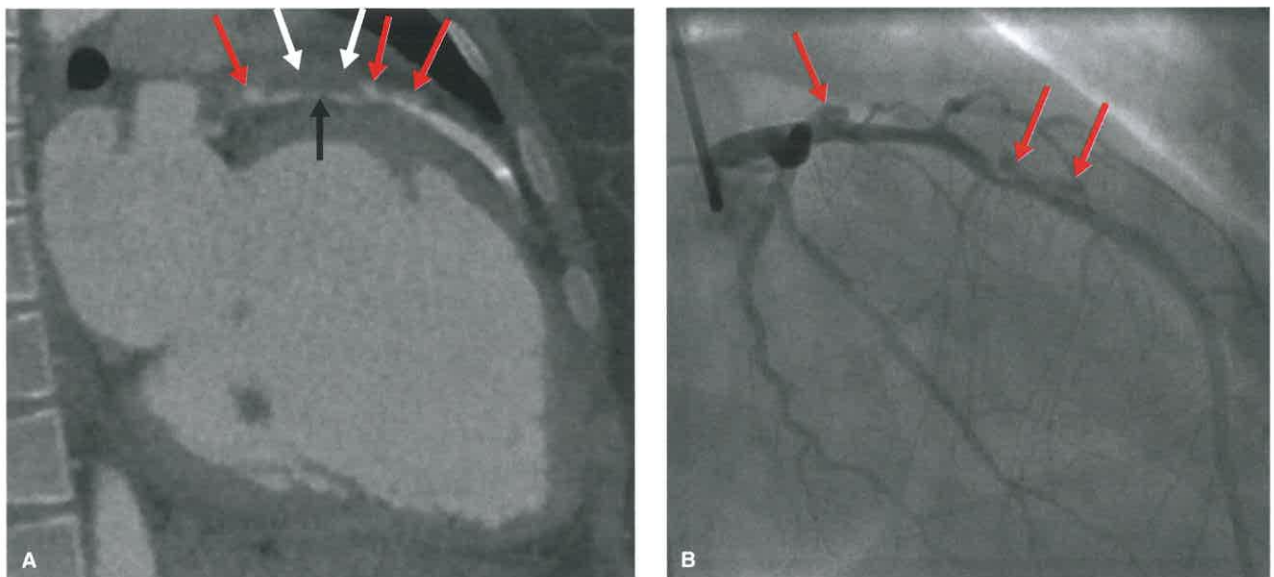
A 24-Year-Old Woman With a History of Spontaneous Coronary Artery Dissection (SCAD) With Subsequent Stenting After Giving Birth to Her Second Child. A: Longitudinal image through the proximal LAD shows soft tissue attenuation surrounding the vessel corresponding to the thrombosed false lumen (*white arrows*) which compresses true lumen (*black arrow*). There are a few areas of contrast outpouchings that represent persistent filling of the false lumen (*red arrows*). The left ventricle is severely dilated and the patient's ejection fraction was 31%. B: Right anterior oblique image from a coronary catheterization shows areas of persistent filling of the false lumen (*red arrows*) corresponding to the findings on CTA.
